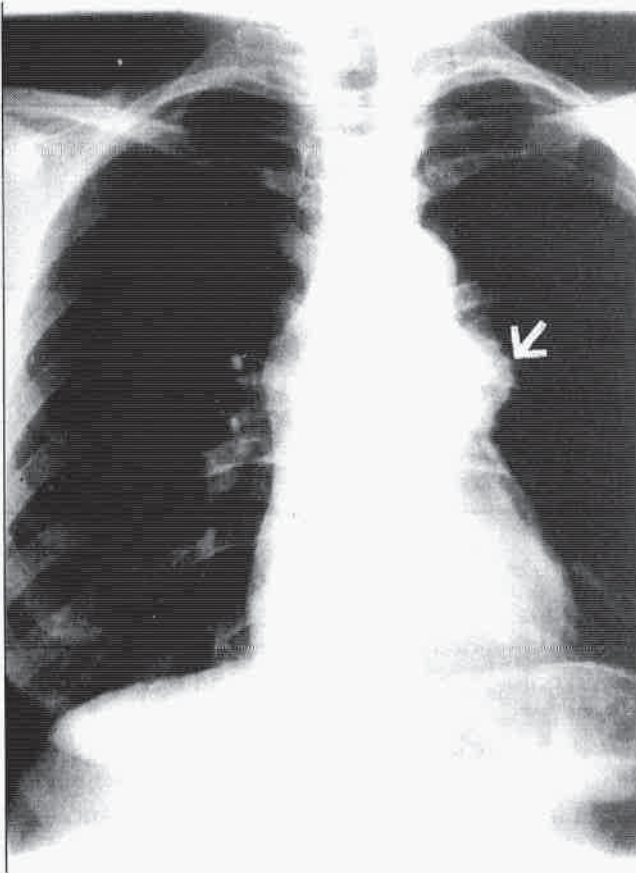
Posteroanterior chest roentgenogram shows a soft tissue mass (arrow) adjacent to conus pulmonalis.
